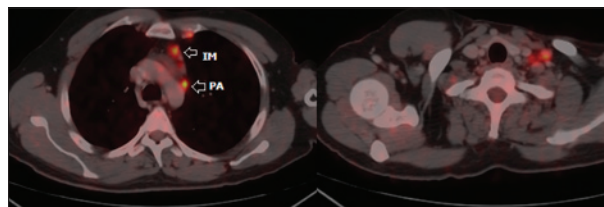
Positron emission tomography computed tomography: Left paraaortic (PA) and internal mammary (IM) lymph nodes (Left image). Left supraclavicular lymph node (Right image)
